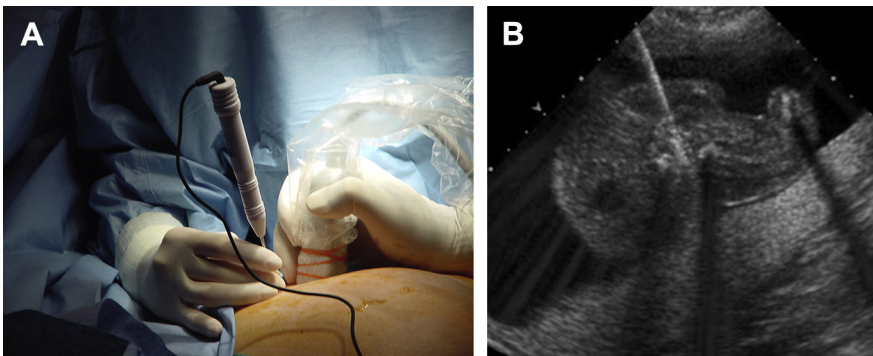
Radiofrequency ablation (RFA) of the cord of an anomalous twin in a monochorionic pregnancy. (A) External view of maternal abdomen with ultrasound and RFA probes. (B) Sonographic view of probe aimed at umbilicus of target fetus.
